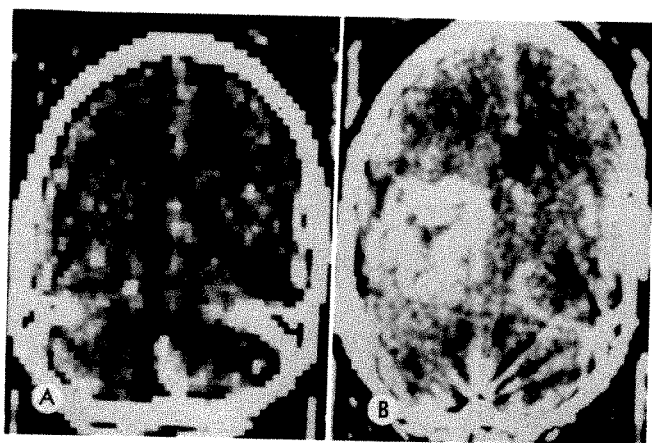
False negative case. *A*, Initial CT with contrast enhancement interpreted as normal. *B*, Same patient 2 months later with contrast enhancement. Large tumor mass with central necrosis, left basal ganglia, and temporal lobe. Glioblastoma multiforme.
